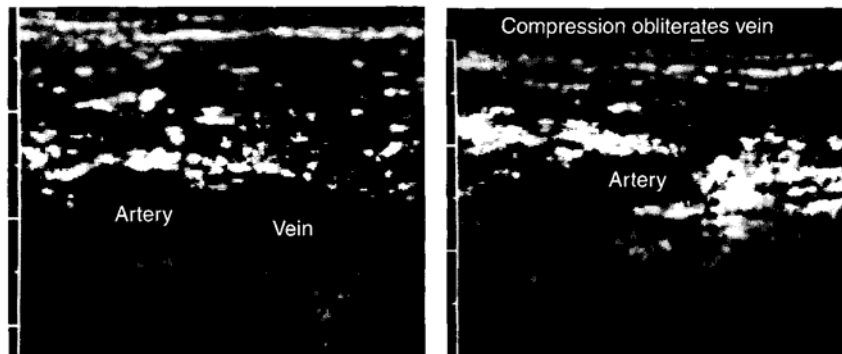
Ultrasound images showing a transverse view of the femoral artery and vein (image on the left) and obliteration of the femoral vein by compression of the overlying skin (image on the right). (From Cronan J, Murphy T. A comprehensive review of vascular ultrasound for intensivists. *J Intensive Care Med* 1993;8:188, with permission.) Images digitally retouched.
